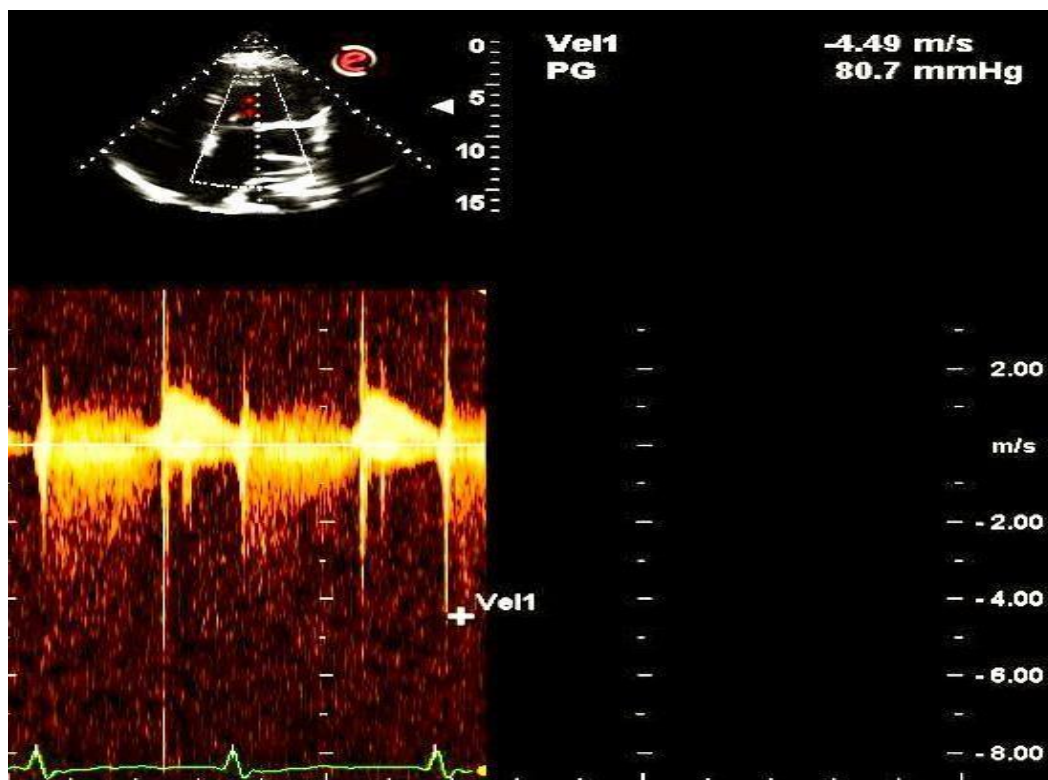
Continuous wave Doppler signal of peak Mitral regurgitation velocity of 4.49 m/sec was observed.
